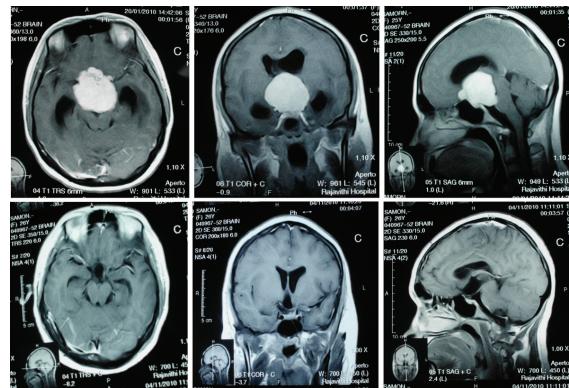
T_1 -weighted contrast enhanced MRI in axial, coronal, and sagittal view of case 3
